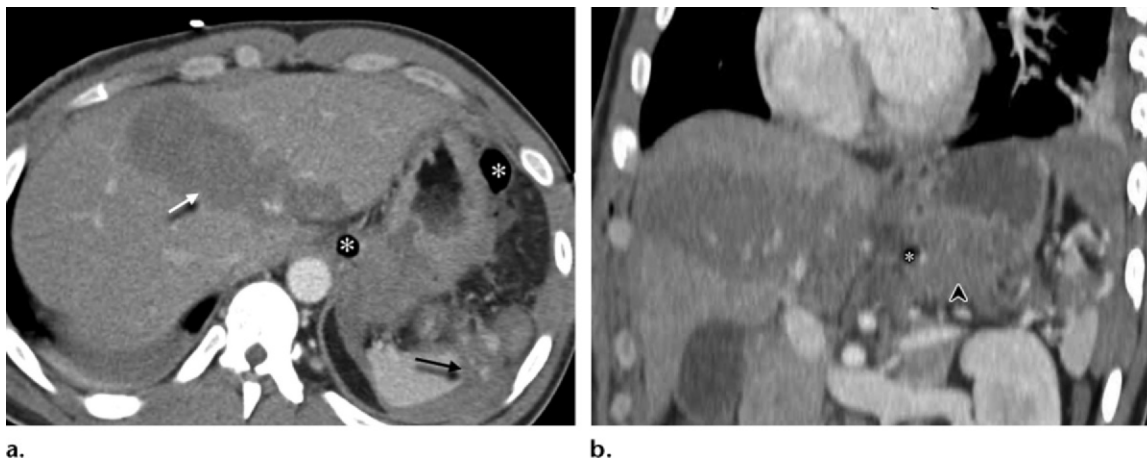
Gunshot wound resulting in gastric perforation. Axial (a) and coronal (b) CT images demonstrate both splenic (black arrow) and liver (white arrow) lacerations. In addition, the trajectory of injury extends through the stomach, resulting in gastric intramural hematoma (arrowhead) and free intraperitoneal gas (*). Perforation was confirmed intraoperatively.
